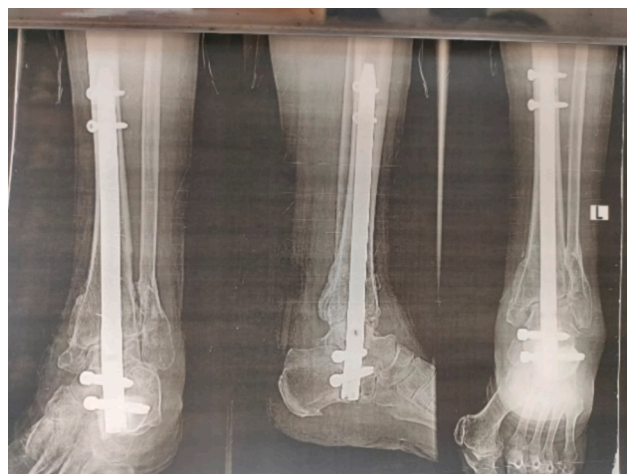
Three months postoperative lateral, AP, and axial radiograph
